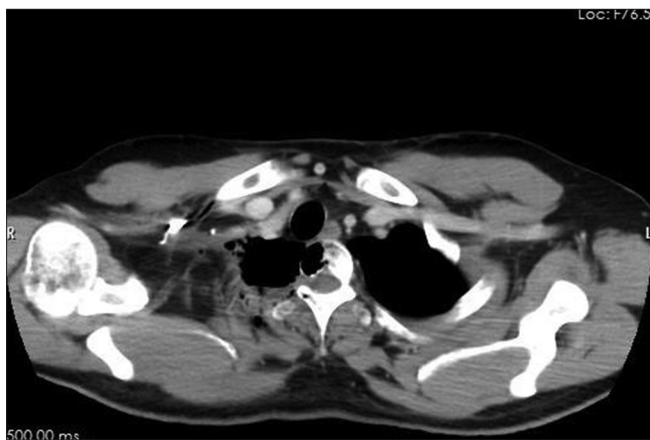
Computed tomography thorax showing osteolysis of the vertebrae and adjacent first rib
